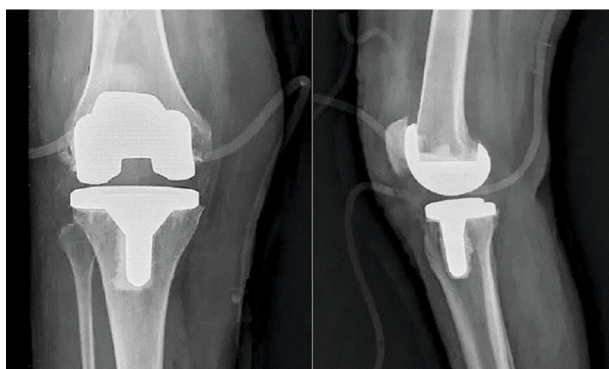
Total knee replacement X-ray [70].
